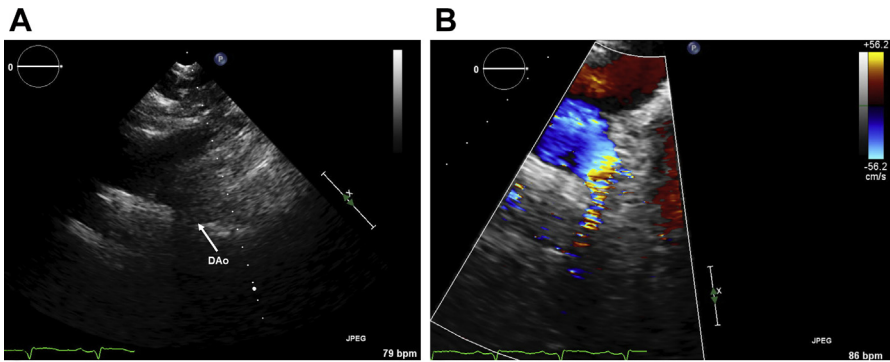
Suprasternal notch view in an obese 62-year-old man with known bicuspid aortic valve and coarctation of the aorta who underwent previous subclavian flap angioplasty. Images suggest narrowing of the proximal descending aorta (DAo) (A). Narrowed appearance supported by color Doppler interrogation (B).
